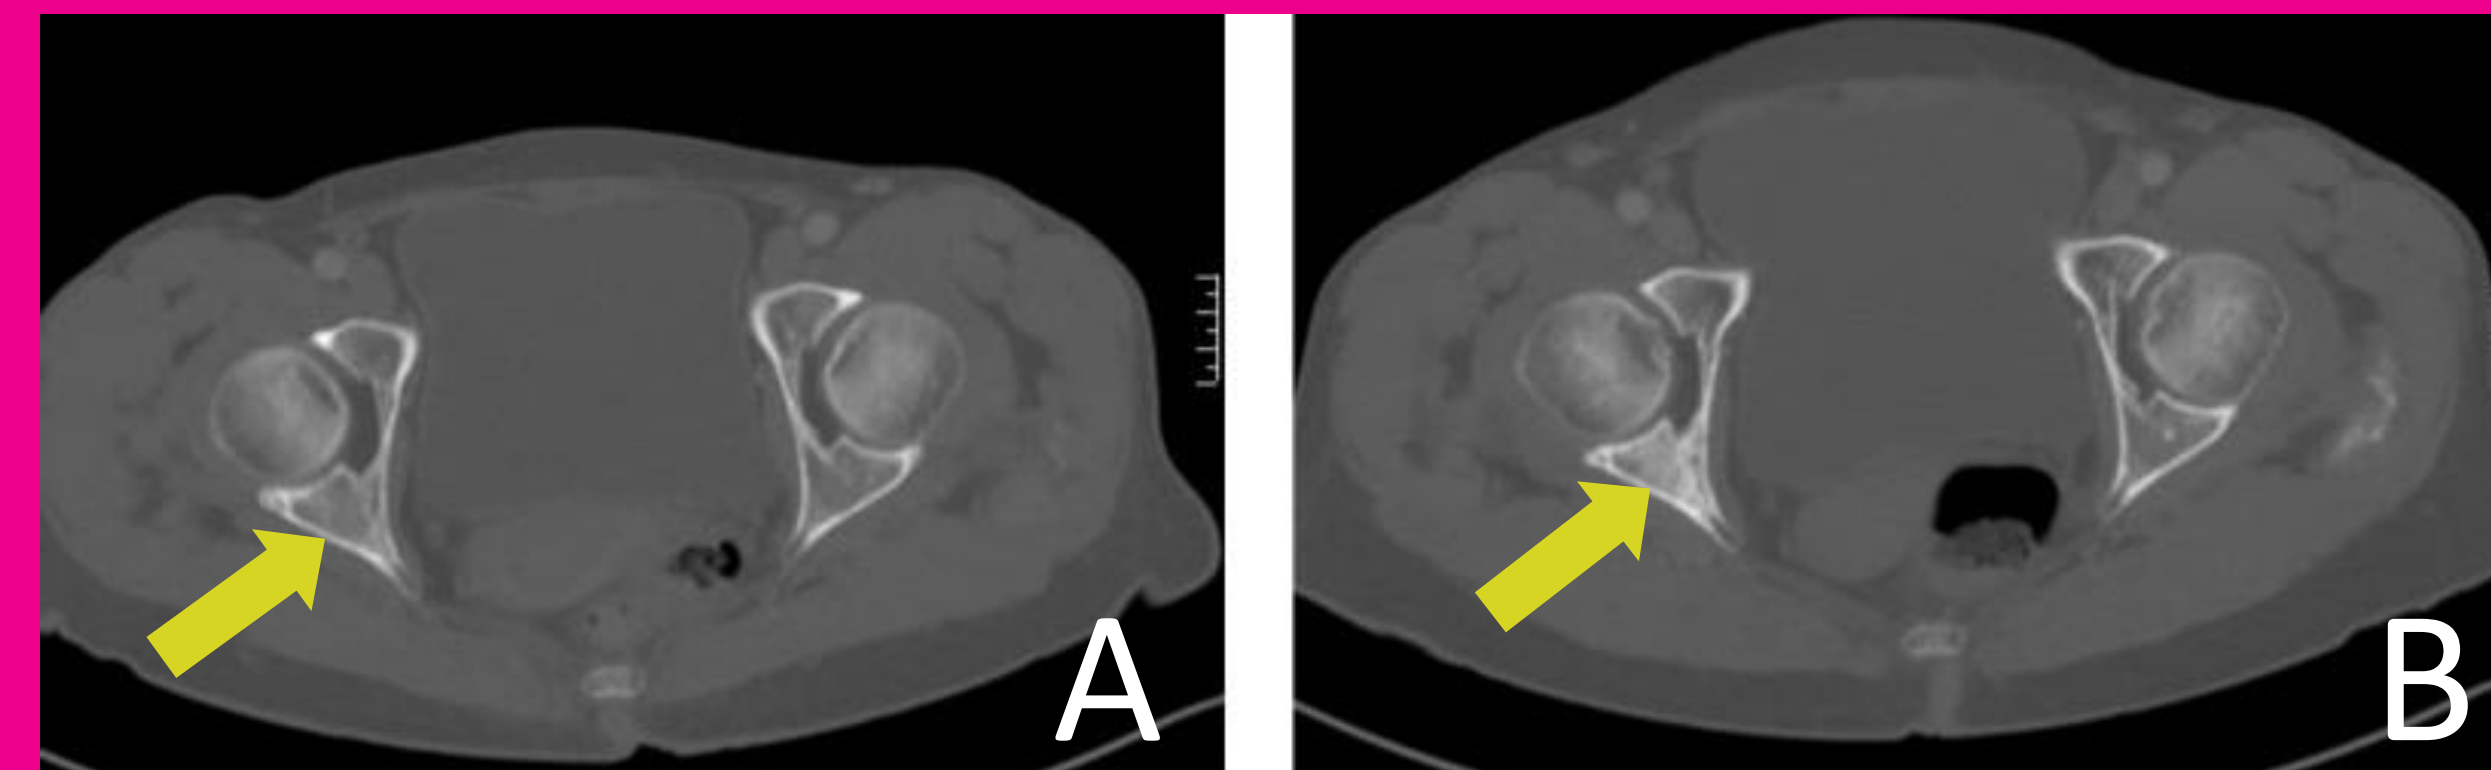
Axial CT of a BC patient with skeletal metastasis on baseline (A) and at follow-up (B). The bone lesion (arrow) is more evident and sclerotic at follow-up.
